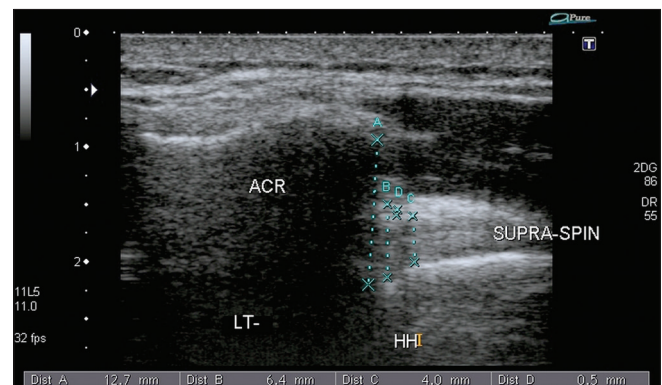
Ultrasound image of the left impinged shoulder in neutral arm position of a 31-year-old male. (A) Subacromial space, (B) Subacromial contents, (C) Supraspinatus tendon thickness, (D) Subacromial subdeltoid bursa. The subacromial contents-to-subacromial space ratio is 0.50 while there was shoulder moment restriction and positive by dynamic sonography in SIS. HH: Humeral head, LT: Left, ACR: Acromion, and (supra-spin) supraspinatus tendon, SIS: Subacromial impingement syndrome
